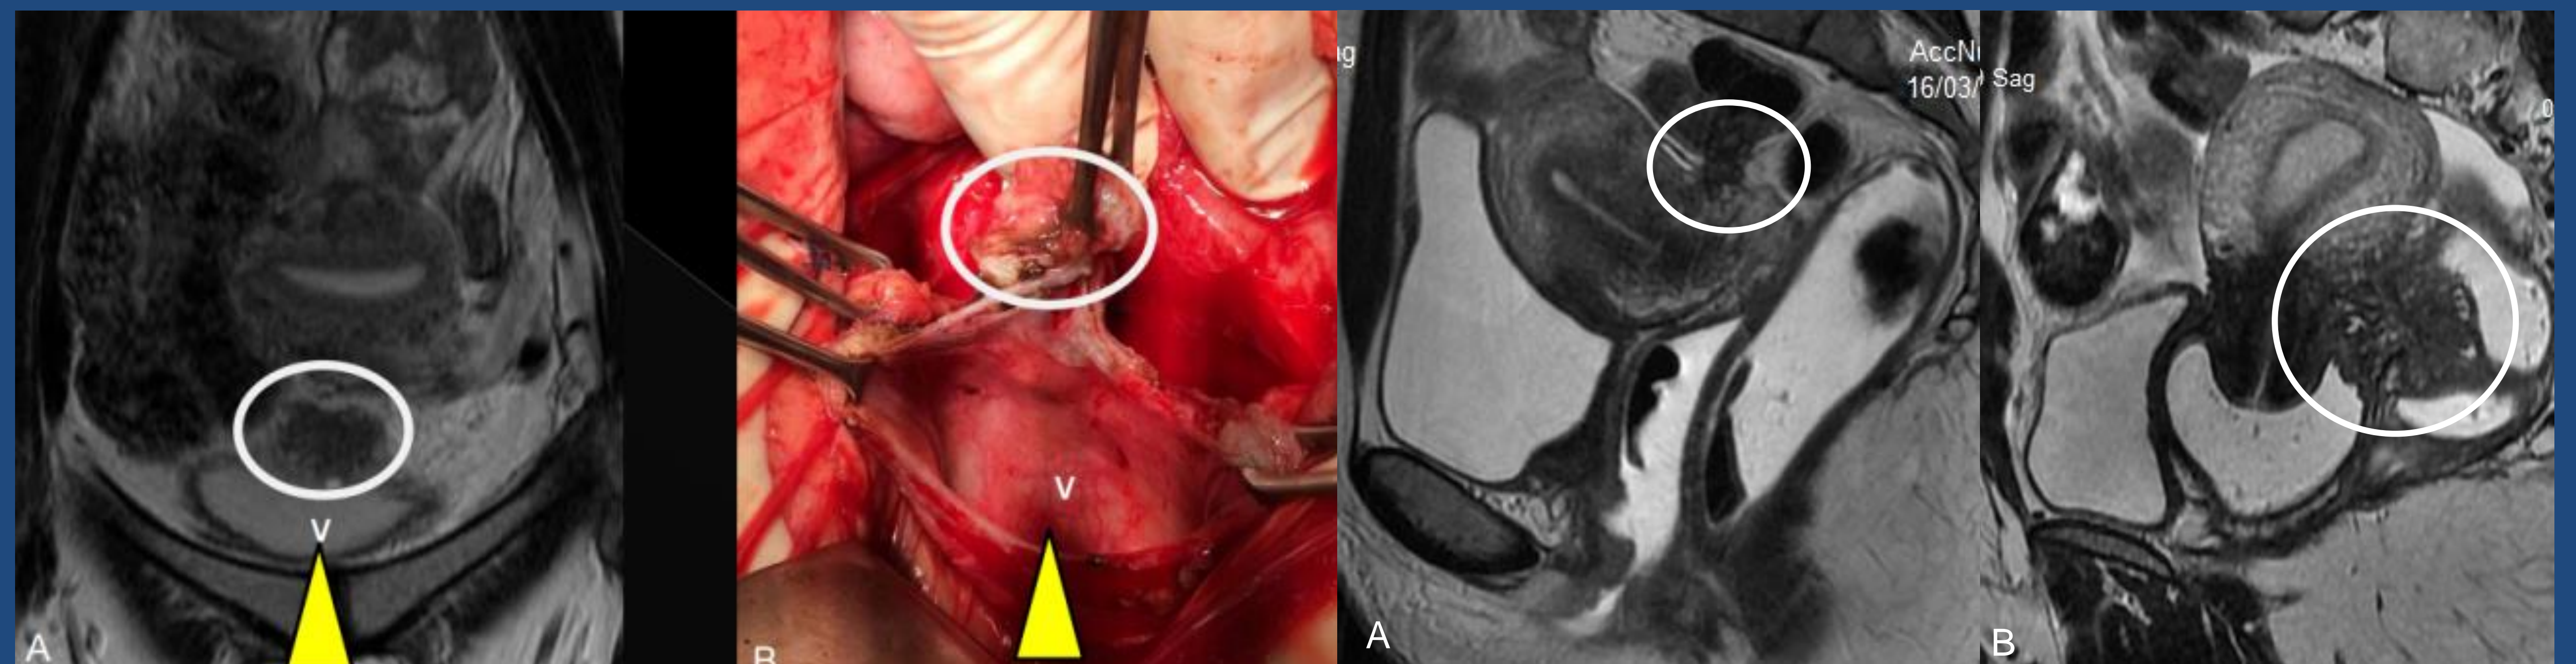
Urinary organs involved (A) Coronal MRI y (B) Intraoperative shows lesion (circle) on the top of the bladder
